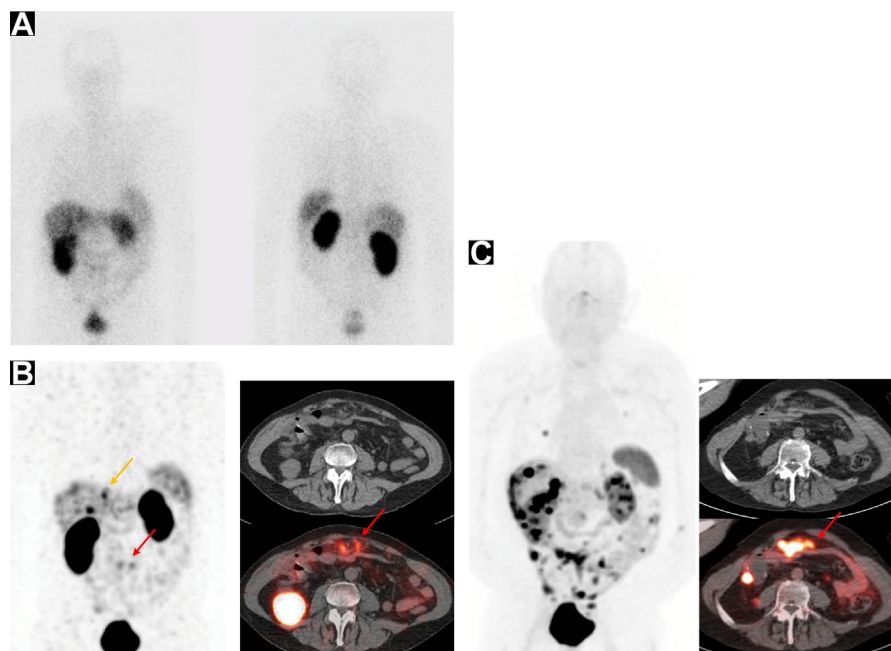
Patient with resected small bowel NET. Faint liver lesions are seen on OctreoScan planar images (A) at 24 hours, more visible on SPECT/CT (B, yellow arrow), with additional peritoneal disease (red arrows). ^{68}Ga -DOTATATE PET/CT (C) shows much more extensive liver and peritoneal metastases (red arrow) and 2 rib lesions.
